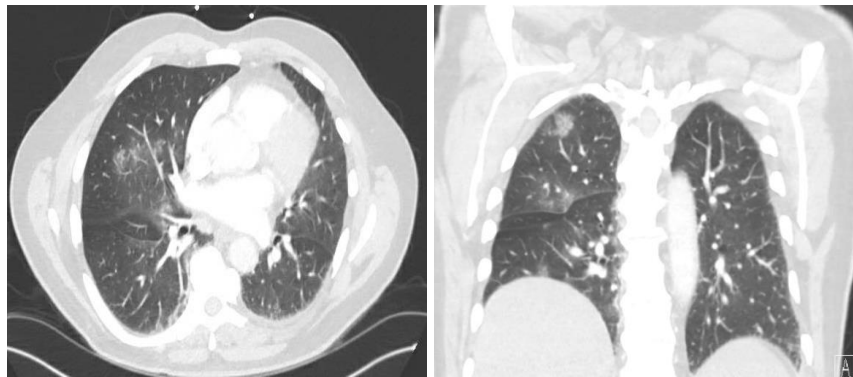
CT Scan of the chest, axial and coronal view with patchy opacities bilaterally.
